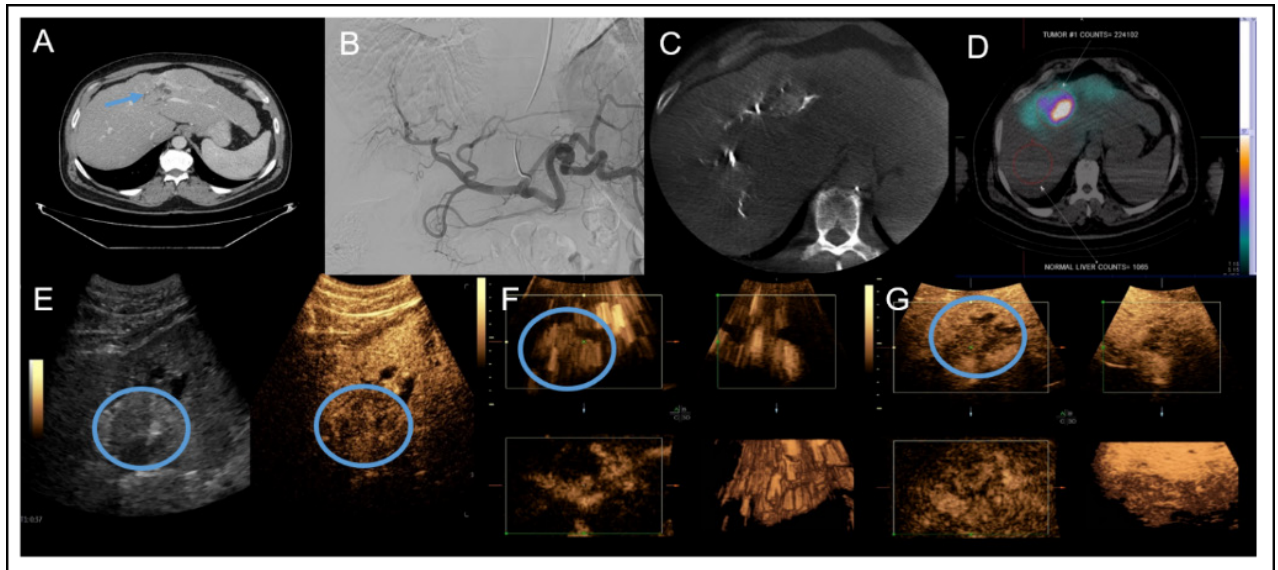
Intrahepatic cholangiocarcinoma in the left lobe of the liver on a pre-treatment contrast-enhanced CT (A). During the treatment planning, angiography (B), cone-beam CT (C), and Tc-99m MAA (macroaggregated albumin) SPECT-CT (D) was performed to evaluate hepatic and tumor feeding vasculature. Dual 2D CEUS imaging immediately post-Y90 TARE treatment (E) 3D UTMD pulse sequences (F) and 3D harmonic imaging to evaluate tumor reperfusion (G). The blue circle indicates the corresponding tumor.
